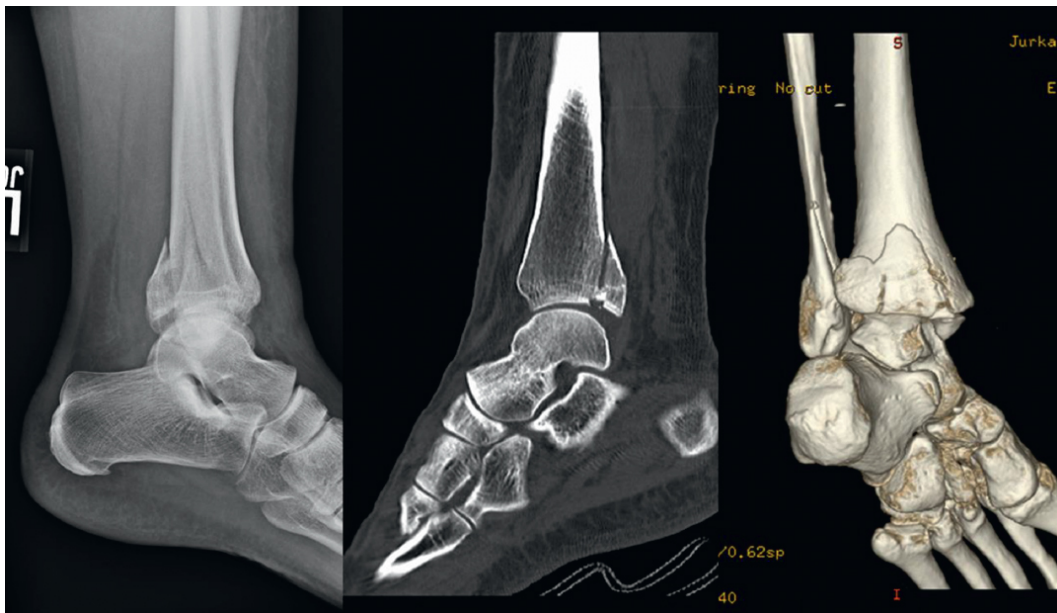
Lateral radiographs and selective CT and reconstructive images demonstrating a large posterior malleolus fracture involving a large portion of the articular surface with an impacted, die-punch articular segment.
